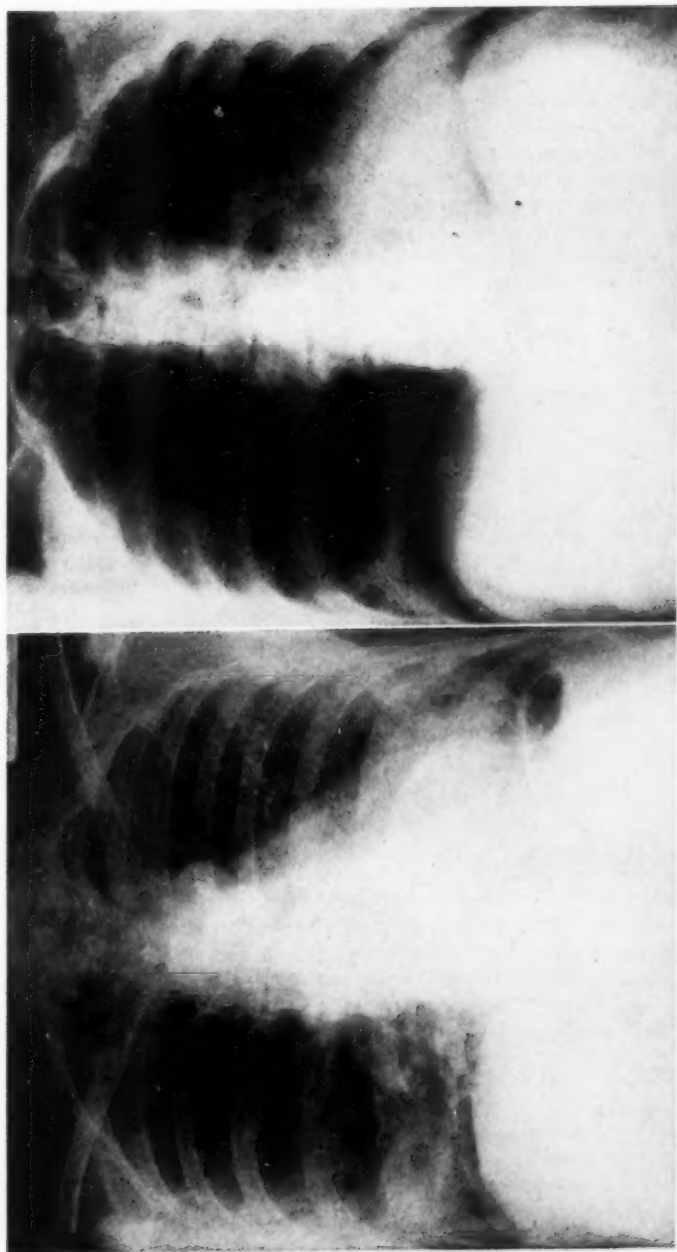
A. Chest x-ray on the thirty-fourth hospital day, showing clearing of the right lower lobe consolidation, with a suggestion of rarefaction in it. B. AP laminagram of the chest on this date at 8 cm. from the film, defining the area of rarefaction, which measured $1\frac{1}{2}$ by 3 cm. and showed a similar smaller area in the left midlung field.
